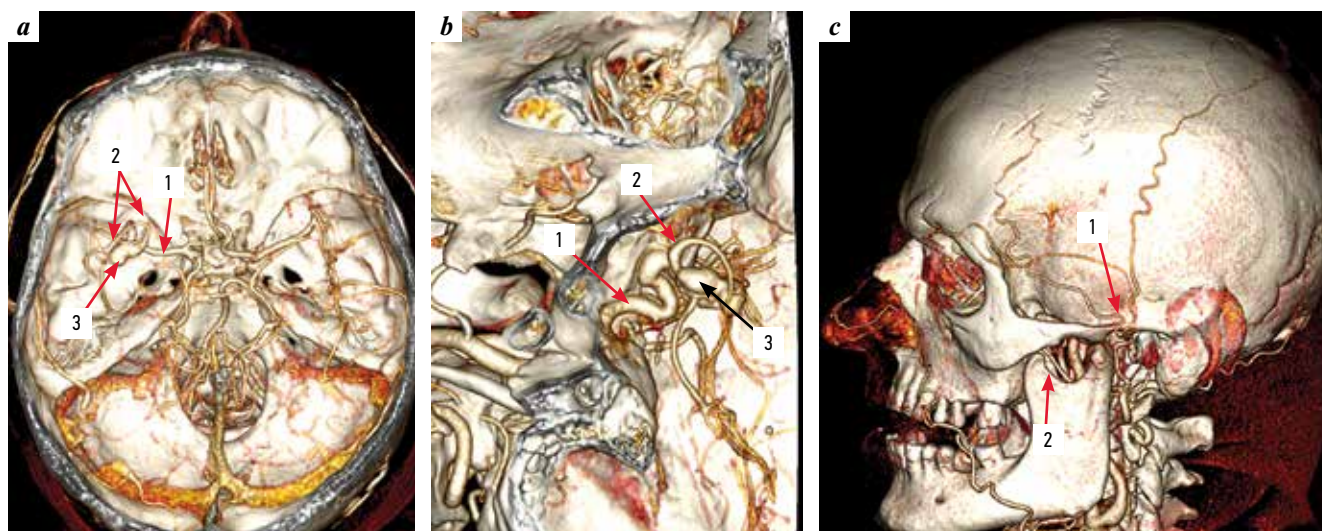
CT angiography before surgery, 3D reconstruction: a – intracranial arteries, axial view: 1 – M1 segment of the left middle cerebral artery (MCA), 2 – M2 segments of the left MCA, 3 – saccular part of the aneurysm of the left MCA bifurcation; b – intracranial arteries, sagittal view: 1 – left internal carotid artery, 2 – M2 segment (frontal branch) of the left MCA, 3 – fusiform part of the aneurysm of the left MCA bifurcation; c – extracranial arteries: 1 – trunk of the superficial temporal artery, 2 – maxillary artery
